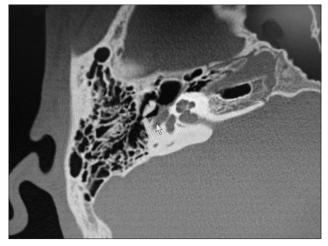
Axial computed tomography temporal bone of the patient showing soft-tissue opacity surrounding the tympanic segment of the facial nerve
